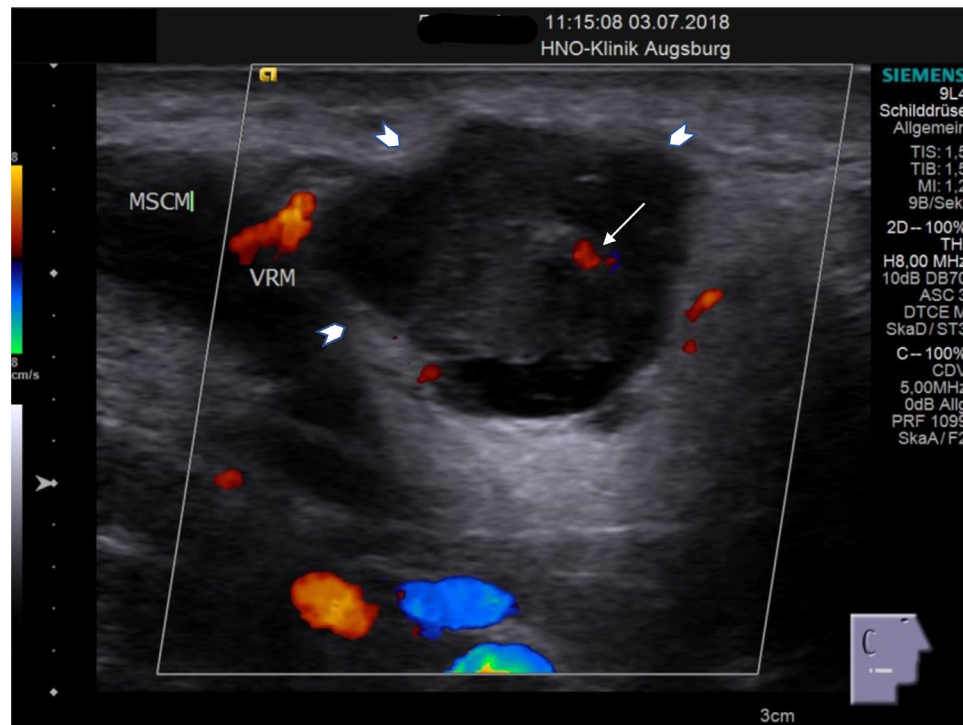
Vascularization pattern on B-mode ultrasound in a pleomorphic adenoma. Central vascularization (*arrow*) of a pleomorphic adenoma with polycyclic lesion margins (*arrowhead*). MSCM = musculus sternocleidomastoideus; VRM = vena retromandibularis.
